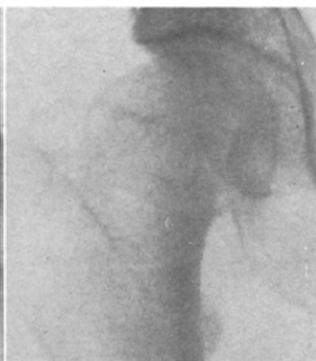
Case xv. Roentgenogram two and one-half years after drilling, November 6, 1936; firm union, fairly well shaped head in fair position; normal bone structure.
